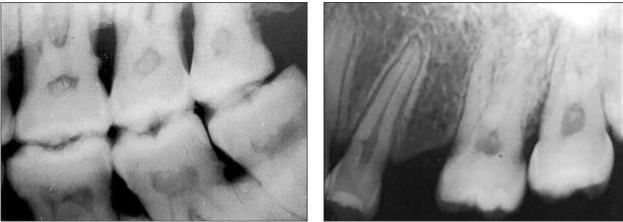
and 69B. Bitewing (A) and periapical (B) radiographs showing posterior pulp stones of varying sizes in the maxillary and mandibular molar teeth.
